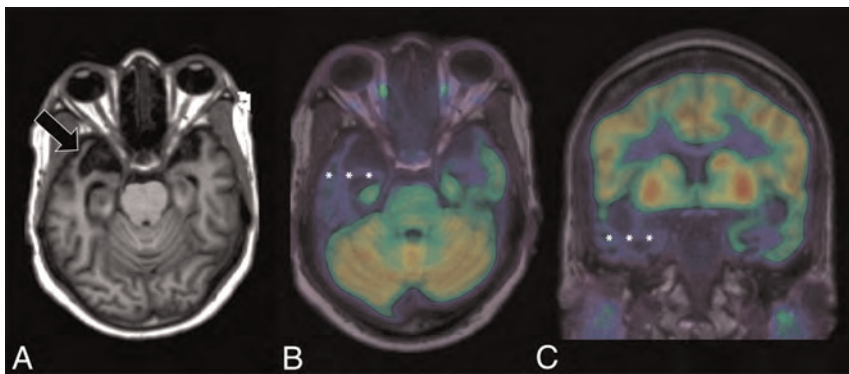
Axial T1-weighted MR imaging (A) and axial and coronal T1-weighted MR imaging fused with [^{18}F] FDG-PET (B and C) in a left-handed individual with impaired single-word comprehension demonstrate marked asymmetric atrophy of the anterior right temporal lobe (black arrow, A) with corresponding marked hypometabolism (white asterisks, B and C) due to svPPA.
